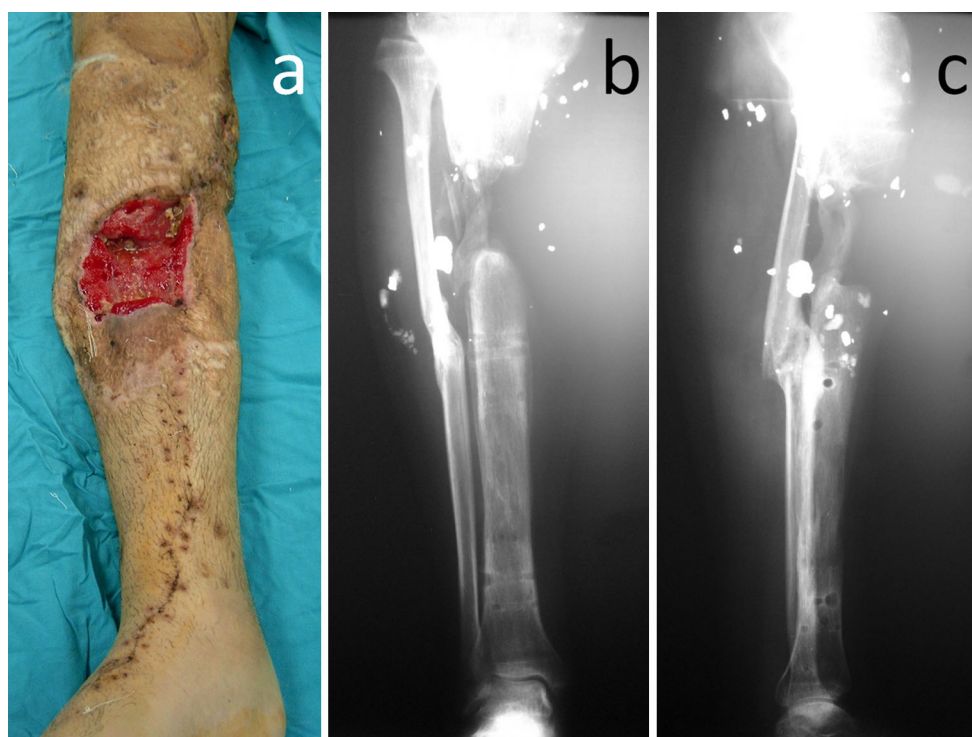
Clinical appearance (a) and the radiographs (b, c) of the patient with bone and soft tissue loss
